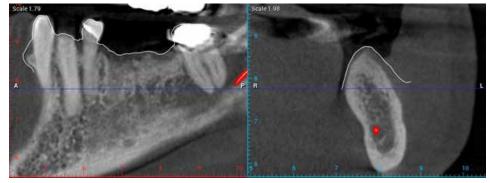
DICOM file of the CBCT with the STL file of the intraoral scan overlayed. Note: the thickness of soft tissue difference between the bone contours and the STL outline. The STL should be well adapted to the contours of the teeth for the best-fit match.
